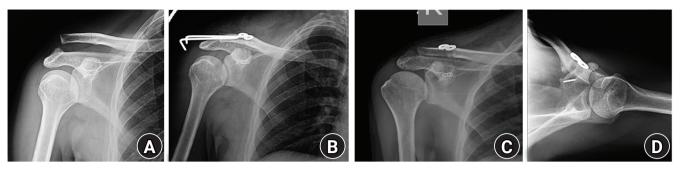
Case example. (A) Preoperative X-ray showing type 5 acromioclavicular joint disruption. (B) Immediate postoperative X-ray with K-wires (C) *in situ* and (D) follow-up anteroposterior and axillary views after 25 months.
